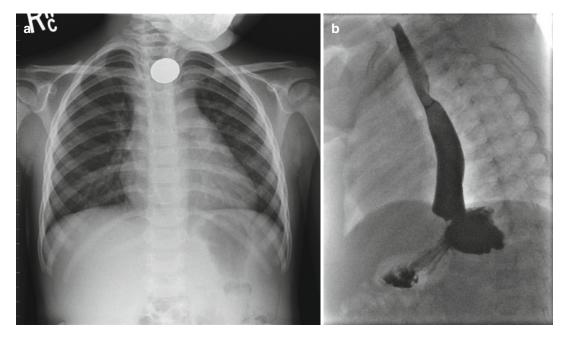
(a, b) Impacted foreign body above an unsuspected vascular ring. (a) Frontal chest radiograph shows a coin lodged in the esophagus proximal to the aortic arch.
